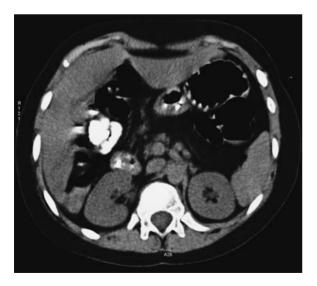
CT image depicts the virtual disappearance of the pancreas in a patient with CF
